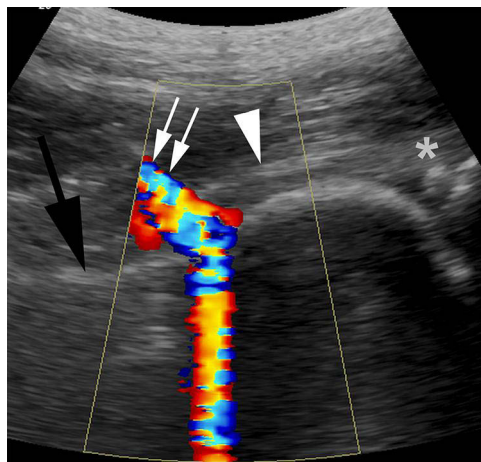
Longitudinal color-flow ultrasound view using color view mode demonstrating injection of combination medication into the hip joint. The path of the needle is shown by the white arrows. The anterior hip capsule is shown by the white arrowhead. The femoral neck is shown by the black arrow. The acetabular labrum is show adjacent to the white asterisk.
